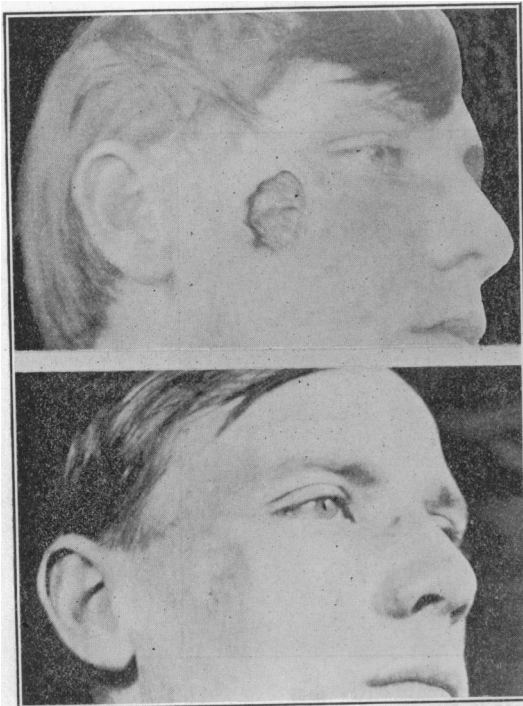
Epithelioma of Cheek, removed four times by knife, healed in three weeks by X-Rays.
